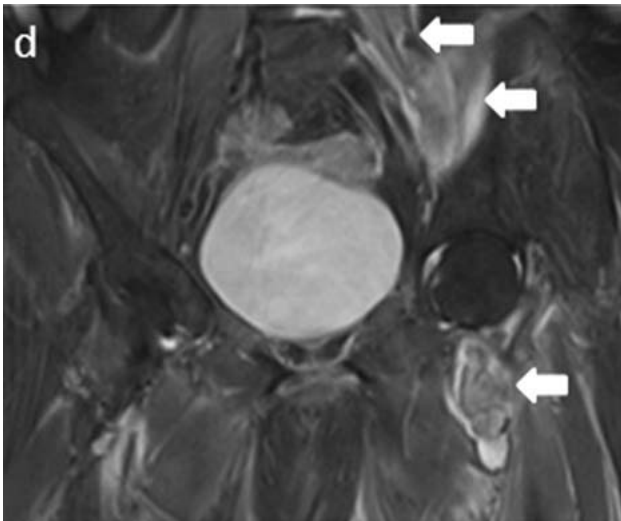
a. MRI pelvis axial STIR sequence. Normal IPT on right side (small arrow). Note soft tissue thickening and fluid at the attachment site of IPT on left side with non visualization of the tendon (long arrow) in keeping with complete tear of left IPT. No abnormal marrow signals are seen in the left lesser trochanter to suggest bone injury. b. Followup MRI pelvis, axial STIR sequence. Interval development of hematoma at the site of injury of left IPT rupture. c. MRI pelvis coronal STIR sequence. Left psoas and iliacus muscle with torn and retracted distal tendon. d. Followup MRI pelvis STIR sequence. Interval development of abnormal signals and edema of left psoas and iliacus muscle suggestive of hematoma.
